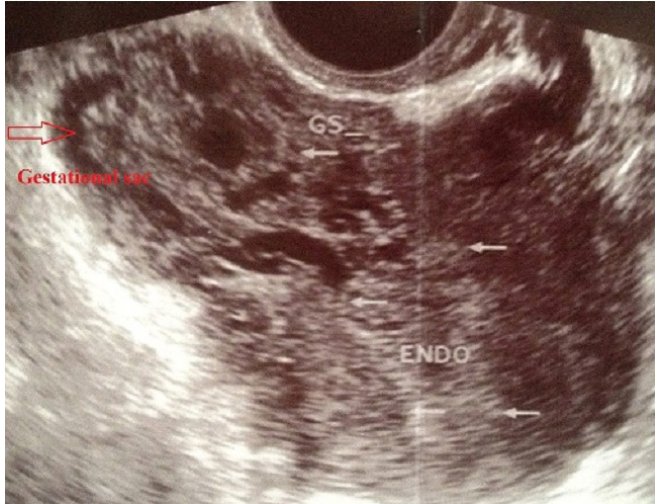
Endovaginal ultrasonography. Ectopic gestational sac was seen in the lower part of the anterior uterine wall at the site of the cesarean section scar with no fetal parts and yolk sac. Endometrial cavity is empty. Red arrow shows GS: gestational sac. Endo: Endometrium.
